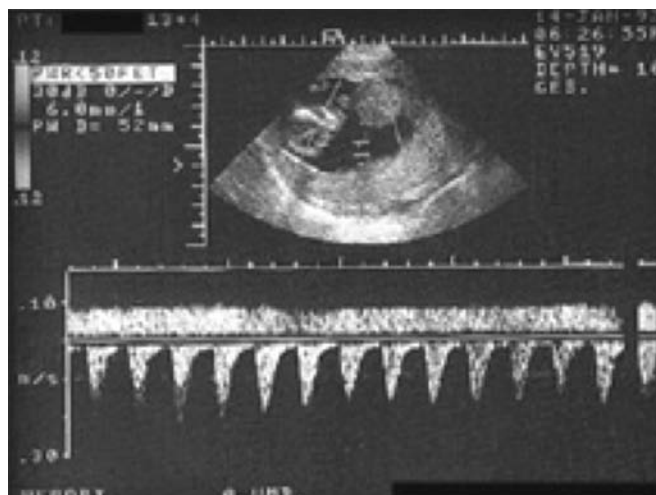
Doppler velocity waveforms of umbilical artery with an end-diastolic flow (lower line) in 13+4 weeks of pregnancy.
